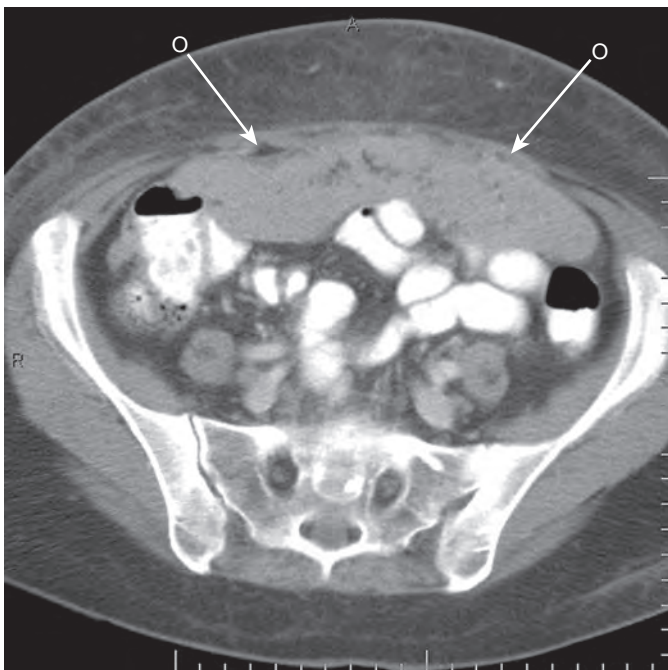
Omental cake. Axial CT demonstrating omental cake (arrows) in a patient with metastatic ovarian cancer.
